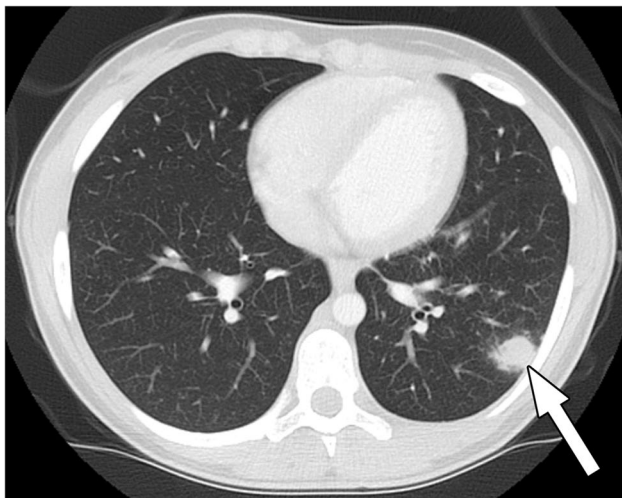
15-year-old girl with acute fungal infection due to histoplasmosis. Axial chest CT image with IV contrast material shows a solitary nodule in the left lower lobe (arrow). The ill-defined margins favor an infectious or inflammatory etiology rather than a malignant etiology
